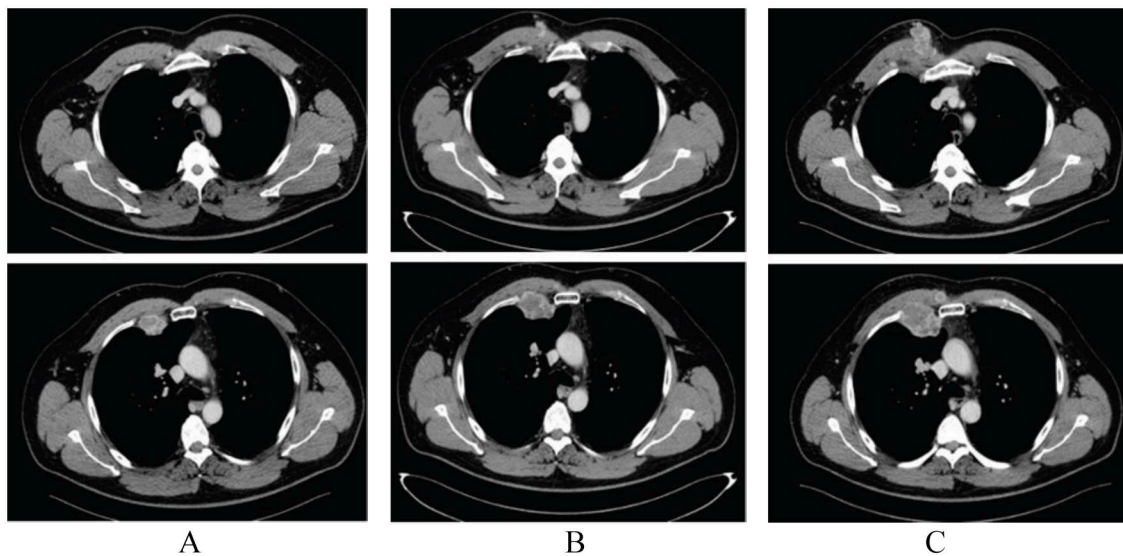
CT scans (A: at baseline; B: after 8 weeks and C: after 16 weeks from the beginning of the treatment) showing the appearance of 2 enlarging lesions in the chest wall close to the biopsied lesion.
